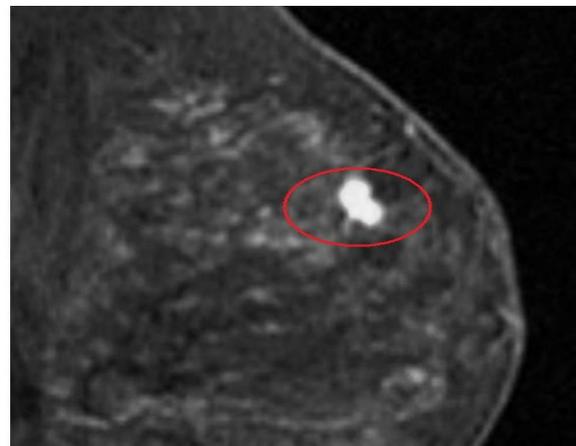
Breast MRI. *Focal* contrast enhancement pattern of a DCIS lesion.
